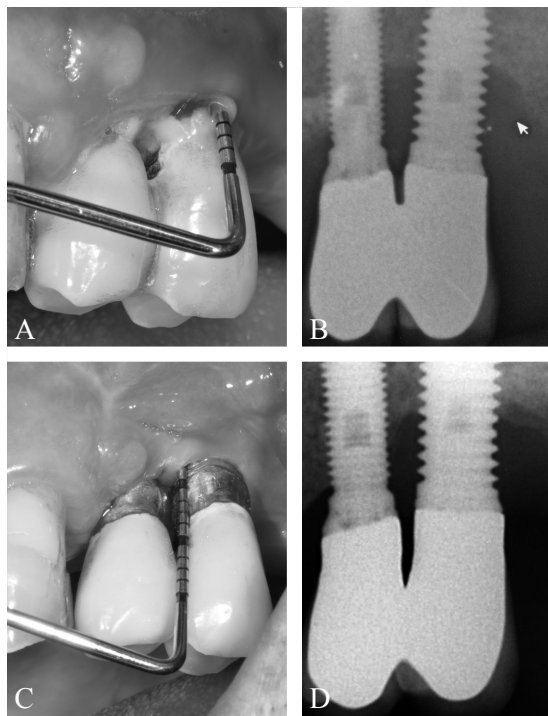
Clinical case: A) clinical baseline; B) baseline X-ray; C) clinical control at 1 year; D) 1-year post-treatment X-ray.
